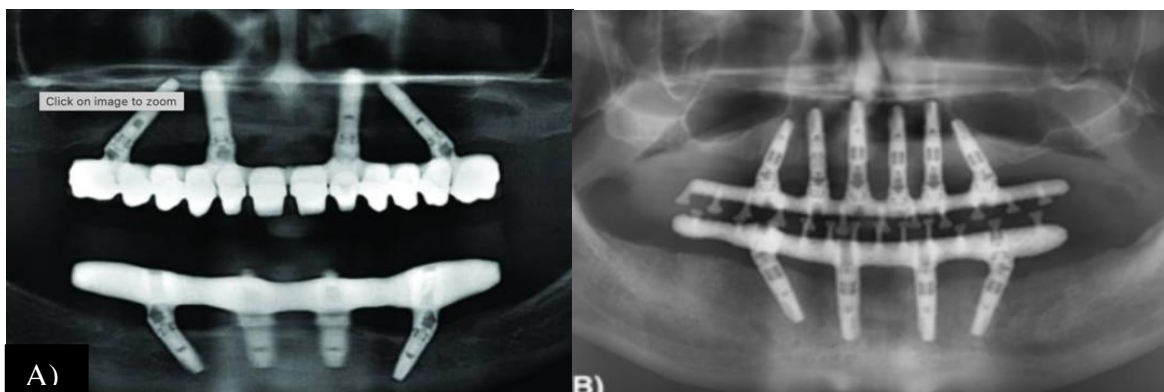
(A) „All-on-four “-concept with 2 axial anterior implants and 2 tilted posterior implants in the premolar area (15), (B) “All-on-six”-concept with 4 axial anterior implants and 2 tilted posterior implants in the molar area (Panoramic radiographs)(16).
